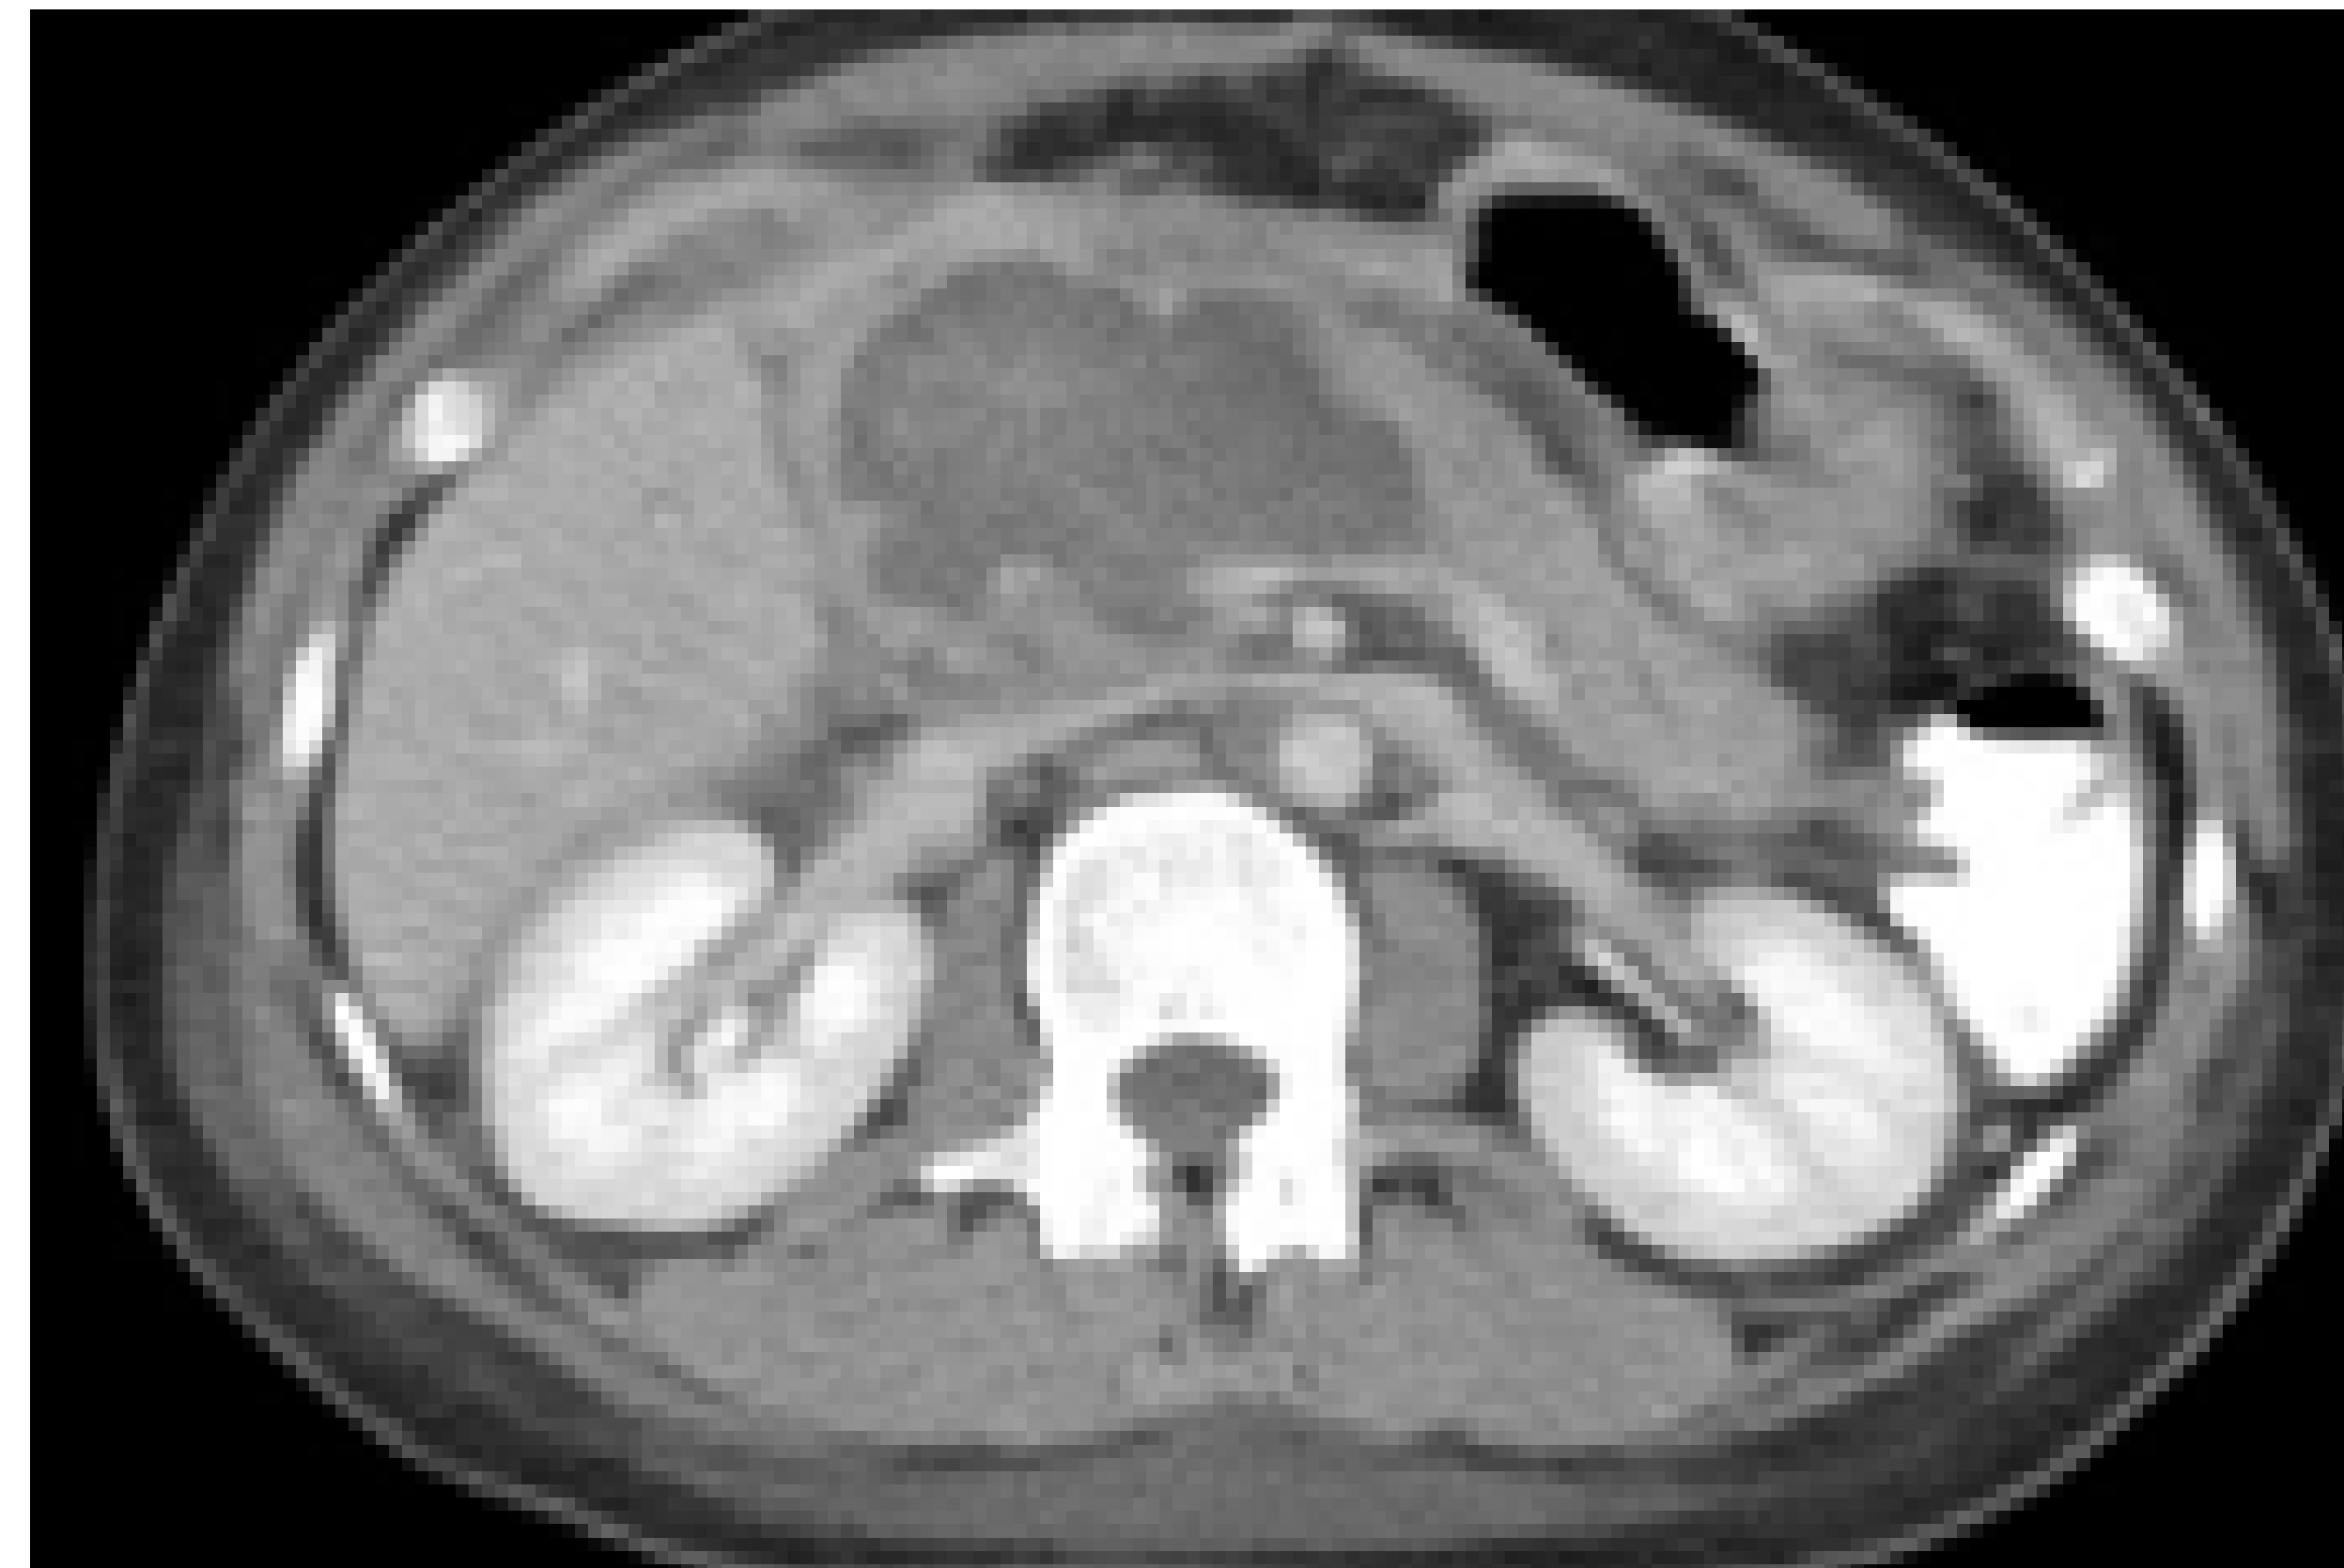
CT A/P (coronal) demonstrating large acute necrotic collection along the proximal pancreas.
